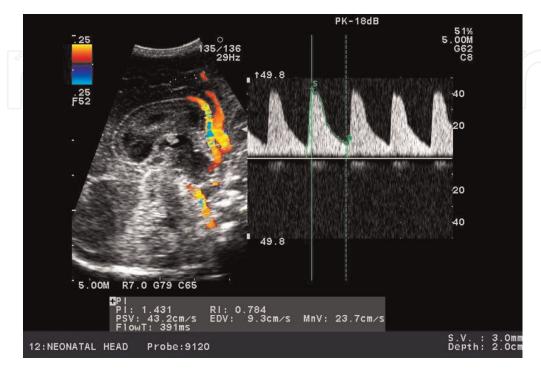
The Doppler curve of blood flow in the anterior cerebral artery (the low-resistive vascular network).
